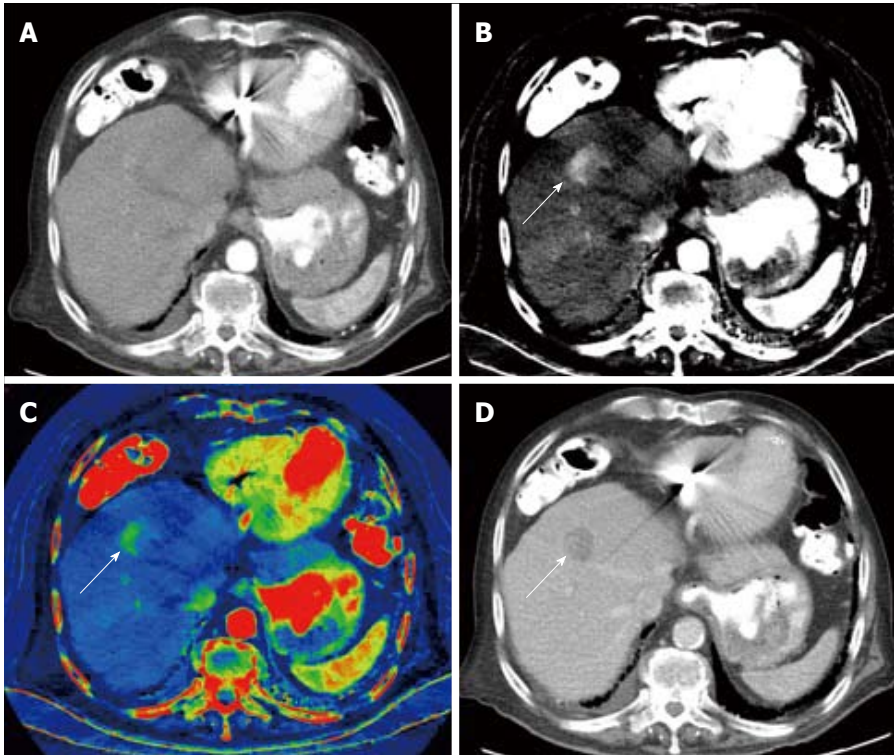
Dual-energy computed tomography of hepatocellular carcinoma. Nodular outline is suggestive of cirrhosis, arterial phase single energy computed tomography (SECT) image acquired at 140kVp demonstrates a vague focus of arterial enhancement that is difficult to differentiate from surrounding liver parenchyma (A), arterial phase DECT material decomposition iodine (MD-I) image shows uptake of iodine independently from inherent tissue attenuation, clearly demonstrating a nodular hyperenhancing lesion (B), arterial phase color overlay MD-I image also depicts the lesion well (C). Portal venous phase SECT image acquired at 120 kVp demonstrates characteristic wash-out (D). MD-I images improve detection and characterization of this small hepatocellular carcinoma. (Courtesy of Drs. Andrea Prochowski and Dushyant Sahani, Massachusetts General Hospital, Boston, MA, United States).
